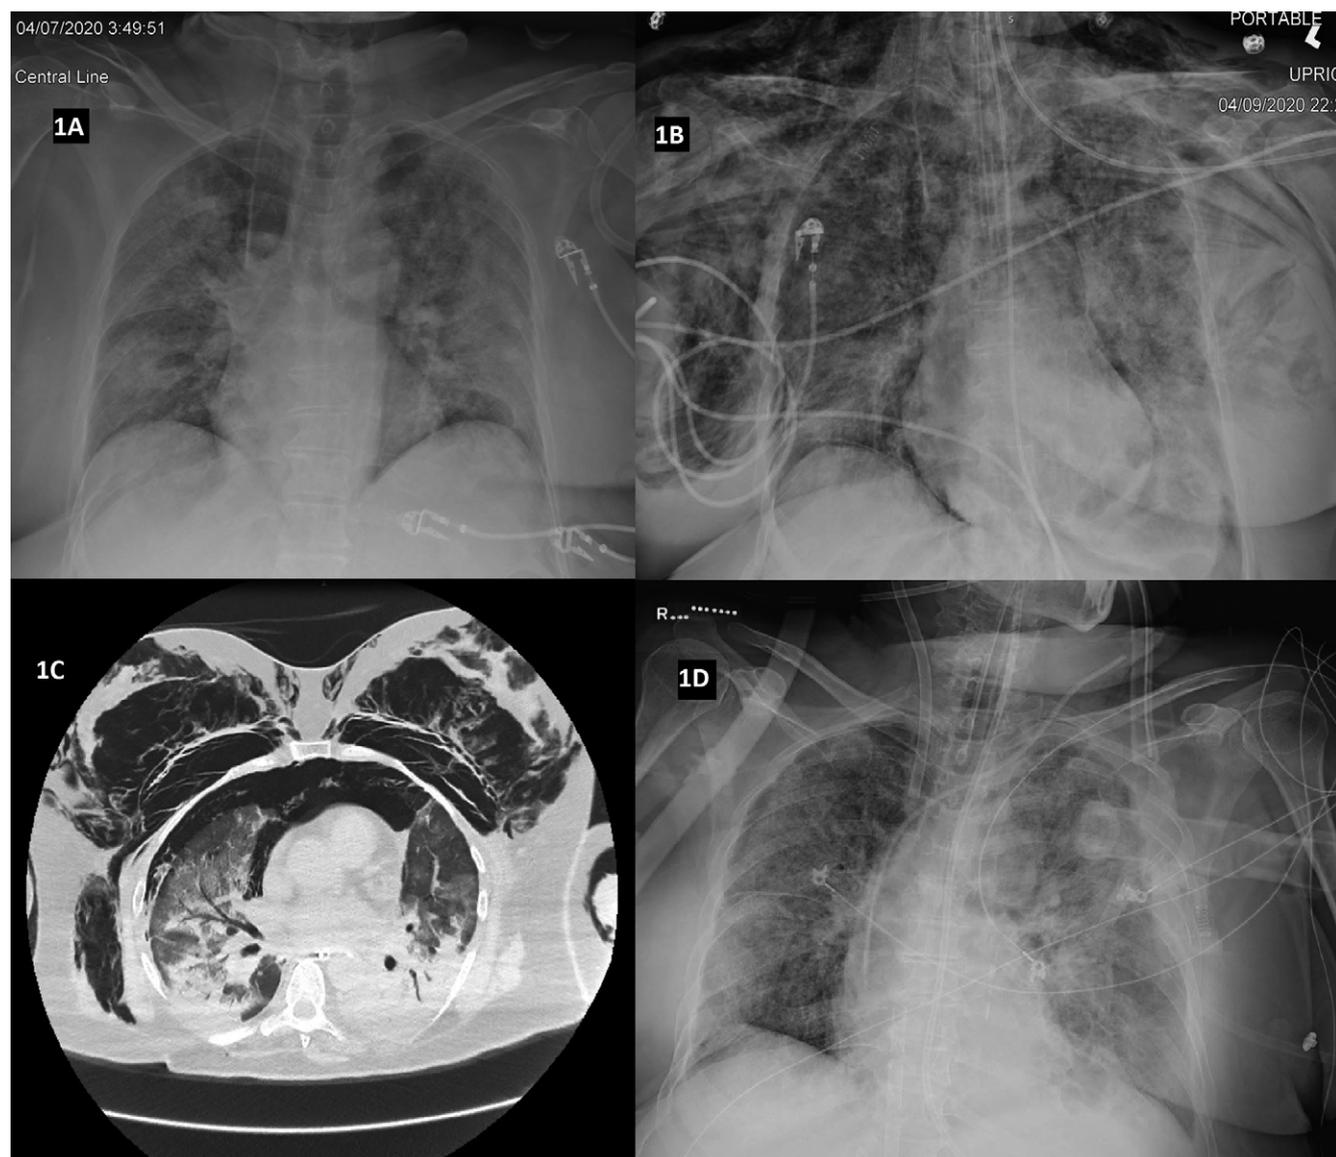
A) Chest x-ray showing bilateral patchy airspace disease. B) Chest x-ray showing severe subcutaneous emphysema in the neck and chest wall bilaterally, questionable right-sided pneumothorax and pneumomediastinum. C) Axial section of CT chest showing bilateral chest wall subcutaneous emphysema, right-sided pneumothorax, pneumomediastinum and bilateral dense consolidations in the lungs consistent with ARDS. D) Chest x-ray showing resolution of previously noted bilateral chest wall and neck subcutaneous emphysema, pneumothorax and pneumomediastinum. Right internal jugular and right femoral ECMO catheters are noted to be in appropriate position.
